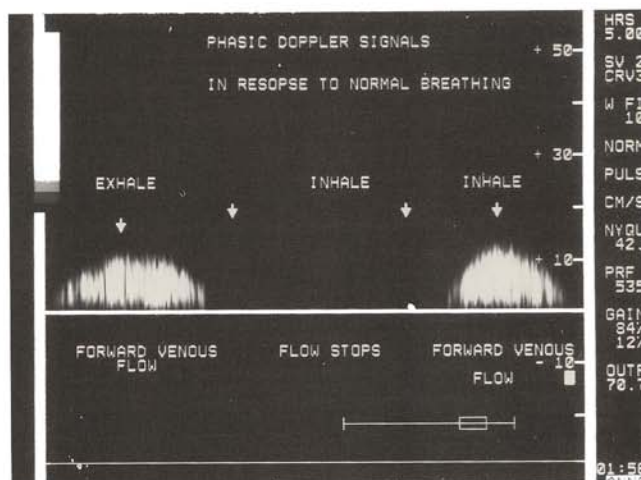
Normal venous flow in phase with respiration. Spectral display of the Doppler signals demonstrates that forward venous flow stops during inspiration and resumes with expiration. This finding suggests that the venous system above the sample site is patent. In this example flow displayed above the baseline represents flow toward the heart.
